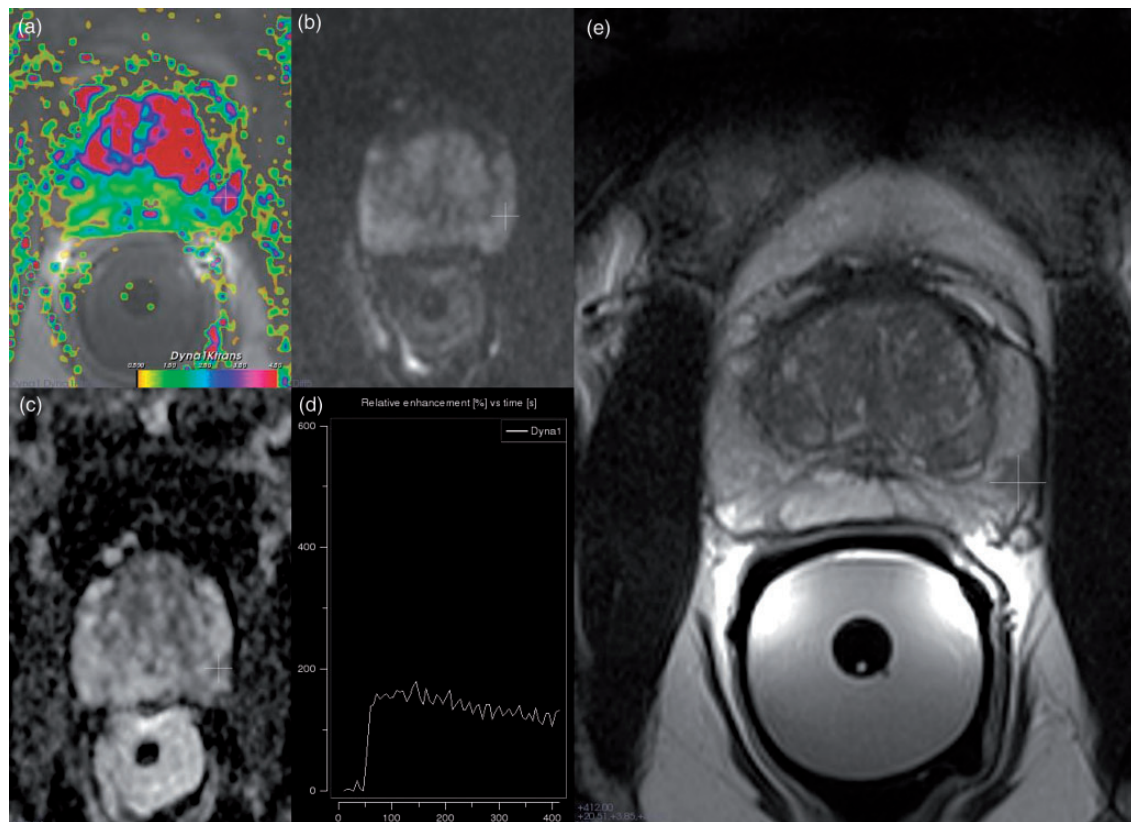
An undetected index tumor in the right side of the peripheral zone with additional PCa detected with mpMRI in the left side of the peripheral zone. (a) DCE Ktrans parametric map: asymmetric enhancement in the left side of the peripheral zone. (b) DWI with b value 800: no obvious area of high signal intensity. (c) ADC map: a lesion with low signal intensity in the left side of the peripheral zone. (d) Perfusion curve: a lesion with curve type 3; fast enhancement, and wash-out. (e) T2W images: a well-defined lesion with low signal intensity in the left side of the peripheral zone and diffuse lower intensity in the right side of the peripheral zone but no obvious tumor by PI-RADS criteria.
